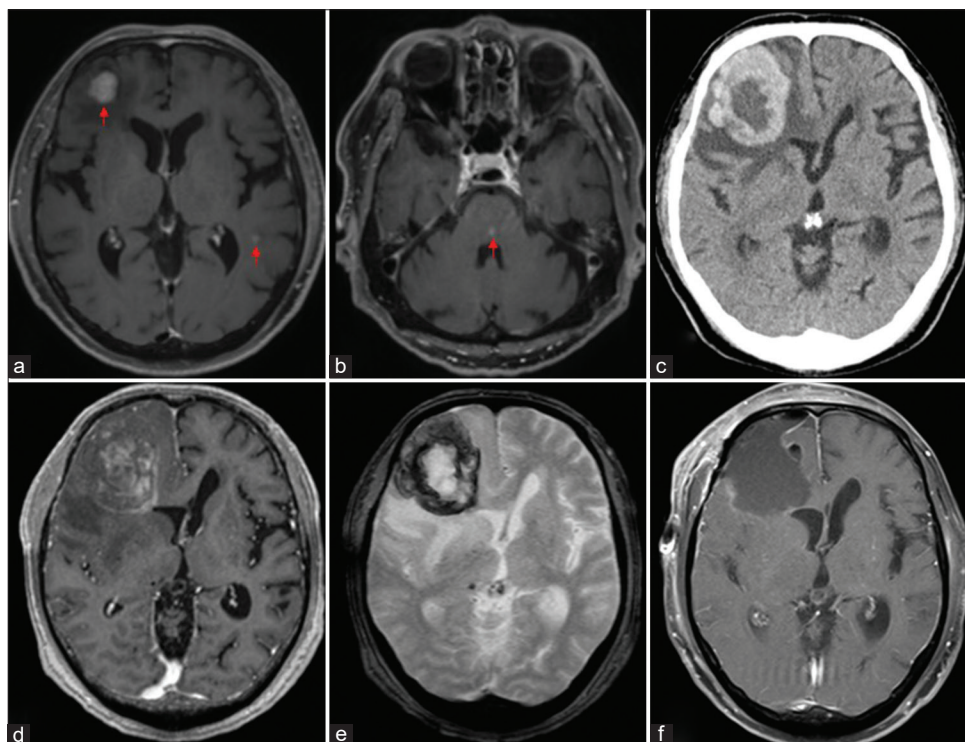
Radiographic features of the metastatic brain tumor derived from leiomyosarcoma of the thigh. Gadolinium-enhanced T1-weighted magnetic resonance imaging (MRI) demonstrating multiple brain tumors (a and b, arrows). Computed tomography and MRI showing the right frontal tumor with a surrounding hematoma (c-e). MRI indicating total resection of the tumor (f).
